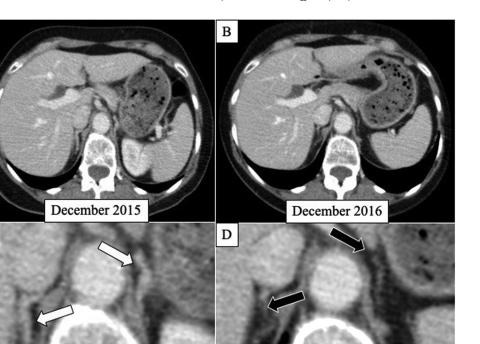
A 66-year-old woman diagnosed with resectable stage III melanoma was treated with anti-PD-1/anti-CTLA4 combination therapy beginning in November 2015. Thirtyeight days after the start of the therapy, the patient started to experience nausea, fatigue, and anorexia progressively, and laboratory analysis revealed increased ACTH levels (976 ng/L), decreased cortisol level (0.06 μ mol/L), and hyponatremia, and the diagnosis of PAI was made. *Following this diagnosis, the patient began corticosteroid replacement therapy with hydrocortisone, later partly replaced by fludrocortisone.* A contrast-enhanced CT scan obtained three days after PAI diagnosis (A, with details in C) showed normal adrenal glands (white arrows). A follow-up CT scan performed 1-year later, in December 2016 (B, with details in D), showed atrophy of both the adrenal glands (black arrows) without mass-like lesions and/or calcifications.
